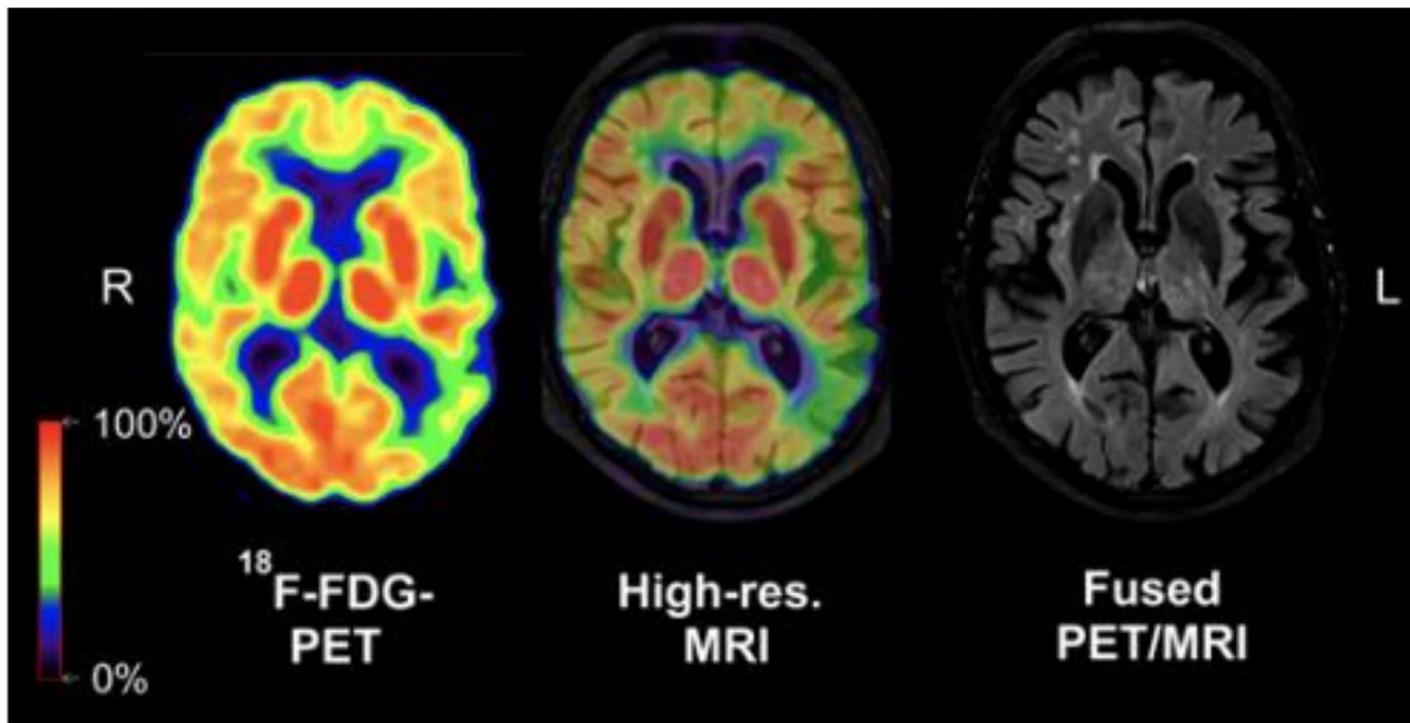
Simultaneous acquisition of PET and MRI images in an AD patient¹⁴
